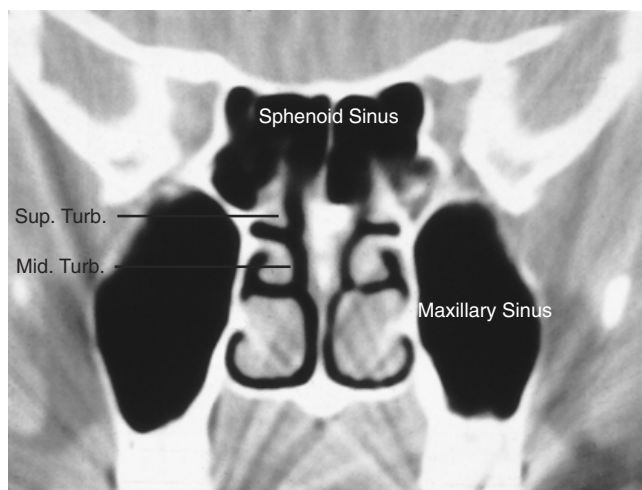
CAT radiograph of the nose. Coronal section view of the sphenoid sinus.
